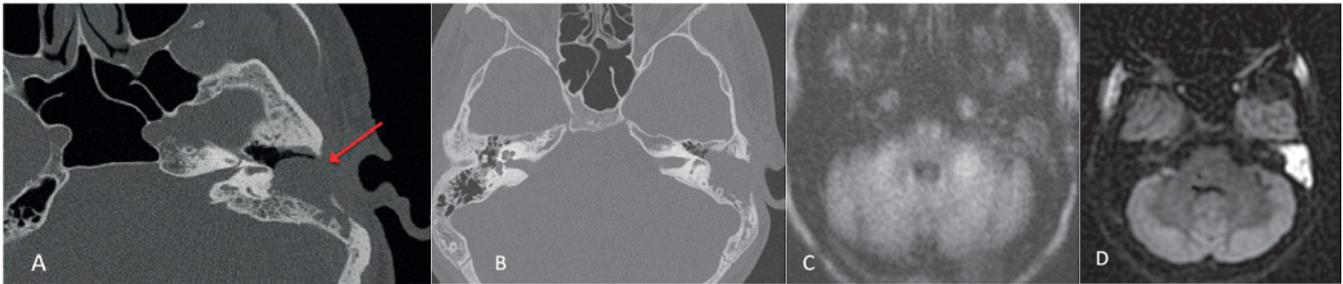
CT images A and B show smooth soft tissue density in postsurgical mastoid bones. DWMR images C and D show the difference between those densities. In C, corresponding with A, the soft tissue is seen to be cholesterol granuloma. In D, corresponding with B, the soft tissue is seen to be cholesteatoma. (Images courtesy of Dr. Eloisa Santiago Gebrim, HC-FMUSP, Hospital Sirio-Libanes, Sao Paulo, Brazil.)
